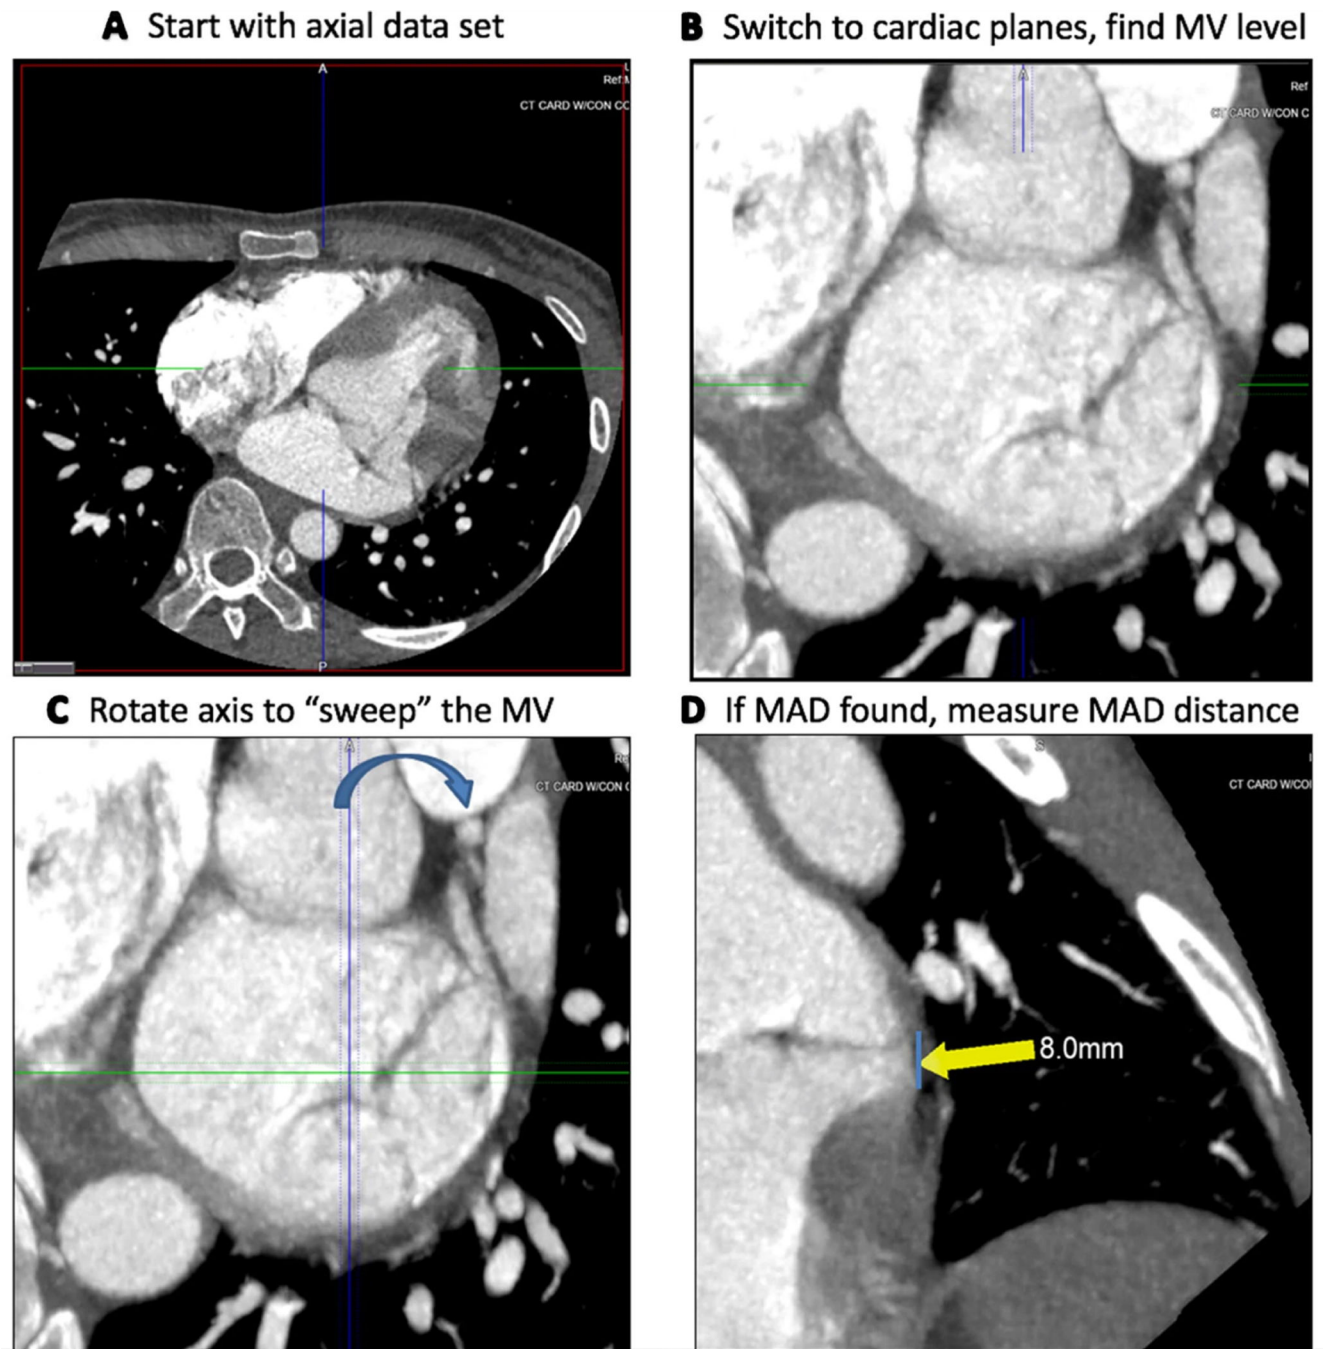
Guide for the CT assessment of MAD. End-systolic phase axial images (a) are loaded and then converted into "cardiac planes" (b). One of the planes going through the mitral valve is rotated (c), while the reader assesses the other two imaging planes for the presence of MAD (d)
